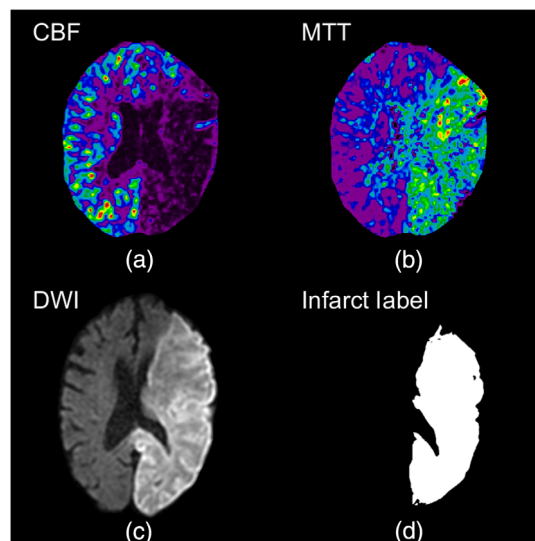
(a),(b) the CBF and MTT perfusion maps for a conservative treatment patient with a complete occlusion of the middle and posterior cerebral arteries. (c) Follow-up DWI with hyperintensified regions indicating infarct. Segmented infarct is indicated as a binary image in (d) with 1s indicating infarct and 0s indicating background and healthy tissue.
